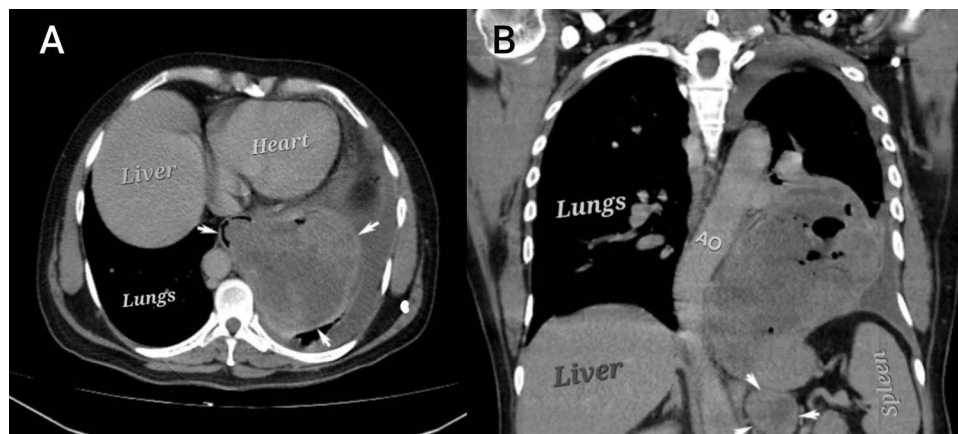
Preoperative contrast-enhanced CT scan (April 6, 2025). (A) Axial CT showing a large, heterogeneously enhancing mass (8.4 × 6.5 cm) arising from the herniated gastric wall (arrows). (B) Coronal CT revealing a round soft-tissue lesion measuring approximately 3.8 × 3.2 cm located posterior to the stomach and abutting the posterior gastric wall (arrows).
